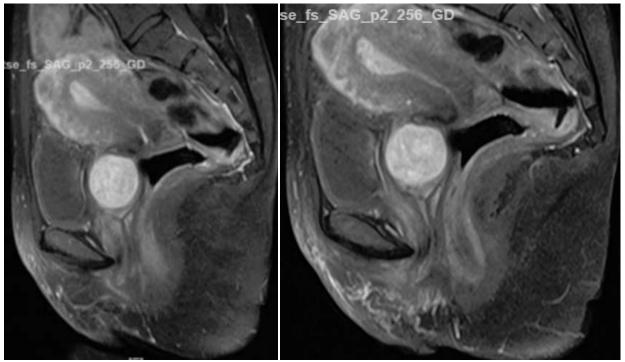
MRI sagital section shows a well defined mass at the level of anterior vaginal wall containing areas of internal cystic degeneration.
